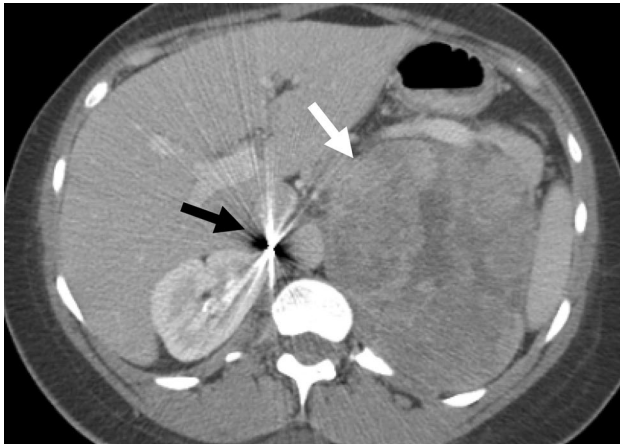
A 32-year-old female patient with left ACC in the context of Li–Fraumeni syndrome. Axial contrast-enhanced abdominal CT shows a large left suprarenal mass (white arrow). Postsurgical changes of a previous right ACC resection are noted (black arrow)
